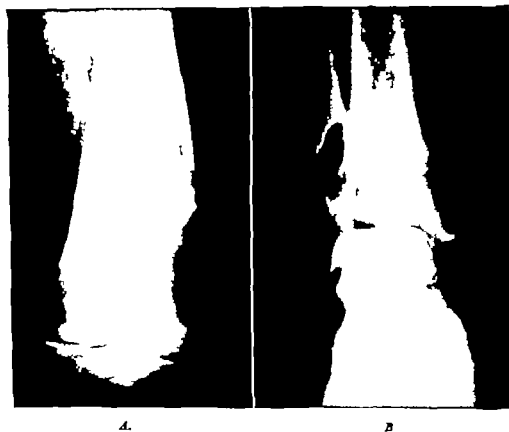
A Representative roentgenogram of a chondromyxoid fibroma situated in the lower shaft and metaphysis of a femur another frequent site of localization. Tumors such as this are sometimes treated more aggressively than is required. B Another chondromyxoid fibroma situated in the lower end of the fibula of a man, aged 30 years. The lesion was known to have been present for 8 years.
